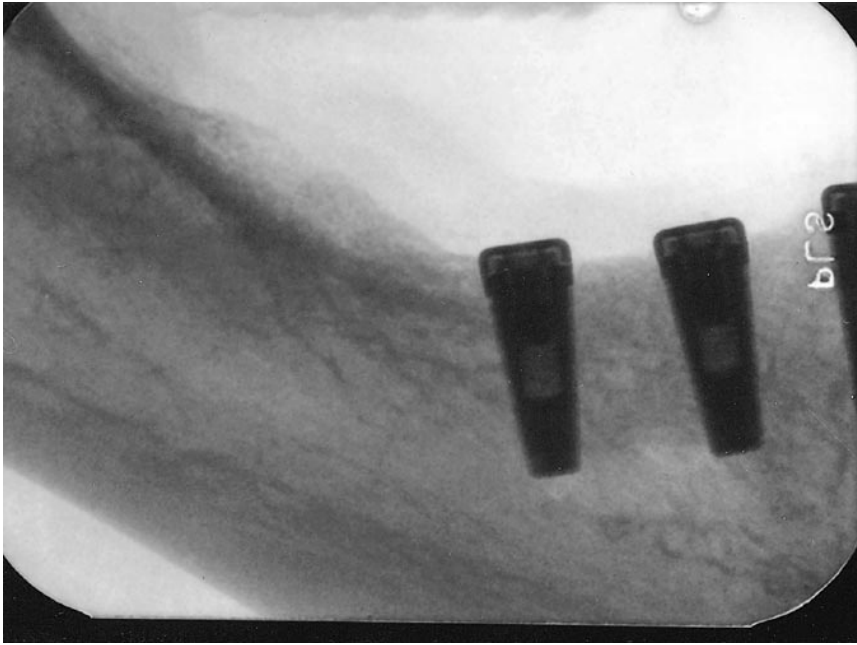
Postoperative x-ray of implant placement.
